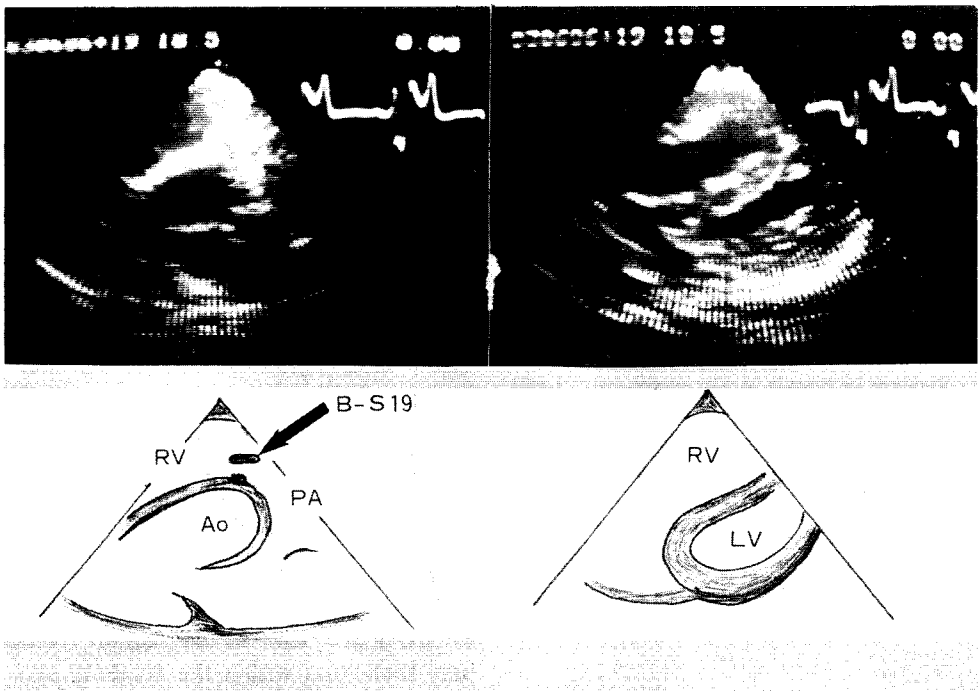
Two-dimensional echocardiograms of case No.1 taken 36 months after operation. Half open and fixed Björk-Shiley valve and marked left ventricular deformity are seen.
